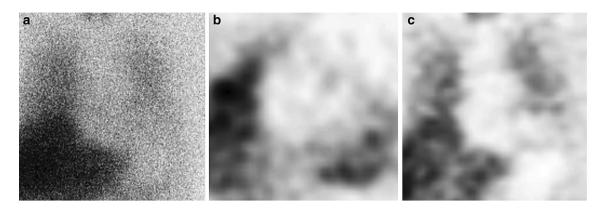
A patient with PD who showed decreased myocardial uptake on both planar image (a), axial (b) and coronal (c) SPECT images
